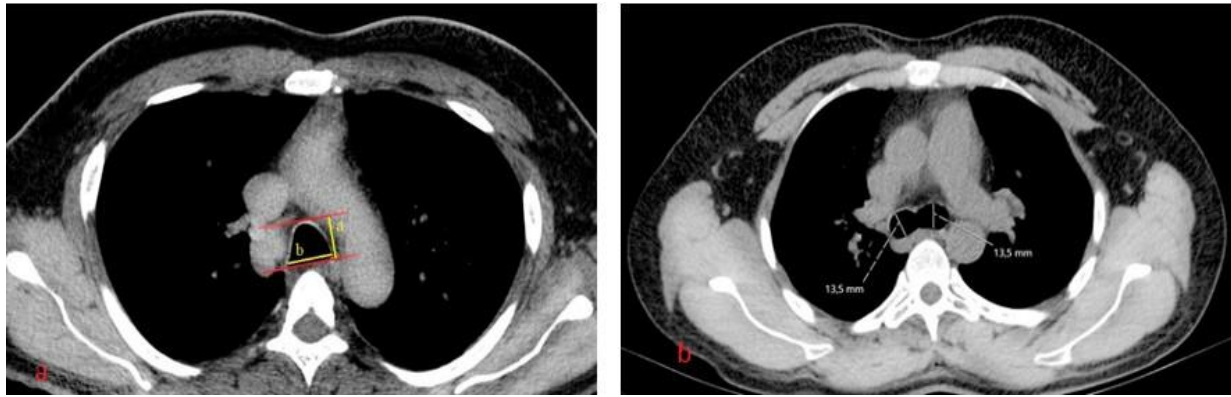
a- Anteroposterior (a) and transverse (b) trachea diameter measurements in the distal trachea from the axial plane CT image, b- Diameter measurements of right main bronchus and left main bronchus from CT image in axial plane.
